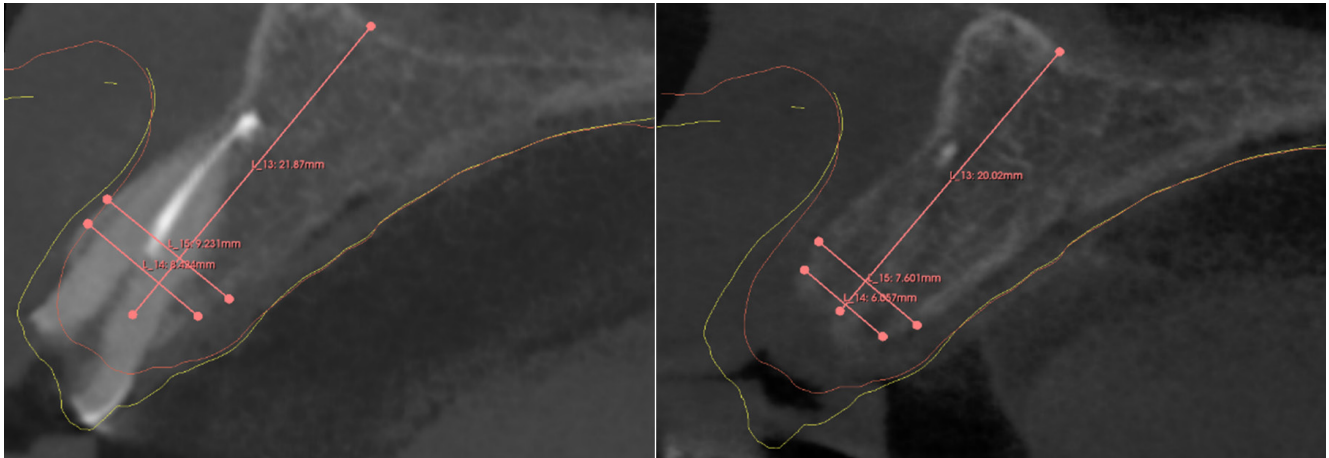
Bone dimensions measurements of the pre and postoperative CBCTs using 3d slicer software
